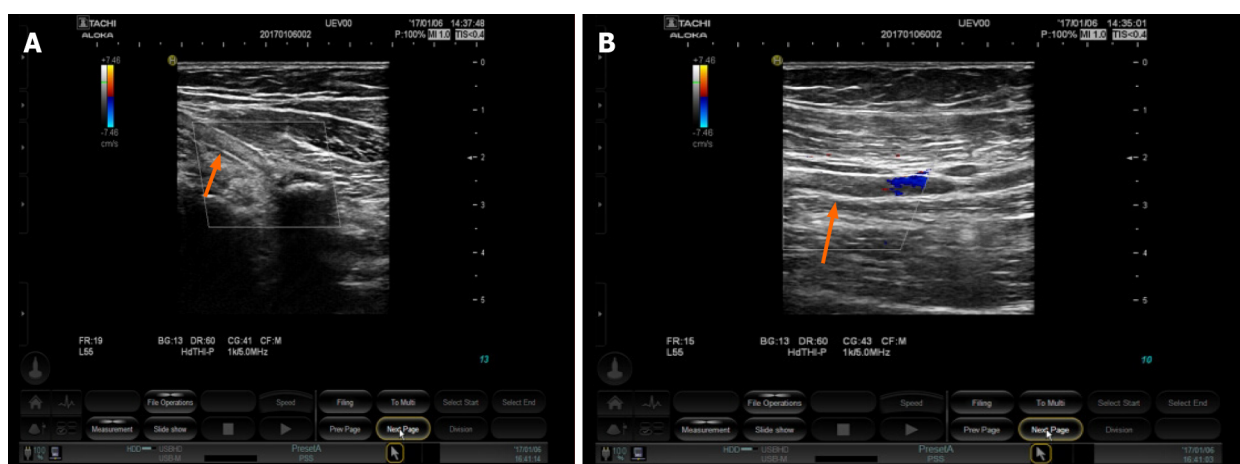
B-mode ultrasound examination of blood vessels showed hyperechoic material. A: Brachial artery; B: Axillary artery.
